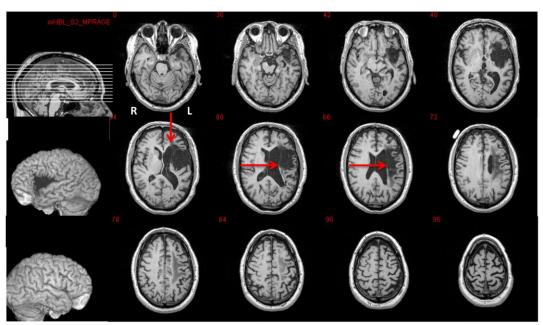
Structural T1-weighted MRI scan for participant HBL. Lesion present in cortex and subjacent white matter (WM) predominantly in left frontal lobe, including most of Broca's area, the insula, motor/sensory (mouth), with extension into portions of the inf parietal lobule, supramarginal and angular gyri, temporal pole and planum temporal; lesion also extended into the basal ganglia and thalamus. Lesion was also noted in the medial scF and middle 1/3 periventricular WM (red arrows), two regions known to be compatible with severe nonfluent speech (Naeser et al., 1989).
